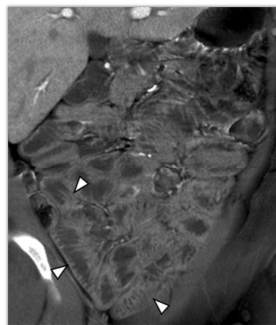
Coronal CT enterography image showing jejunalization of ileal loops noted in right lower quadrant S/O malabsorbtion
